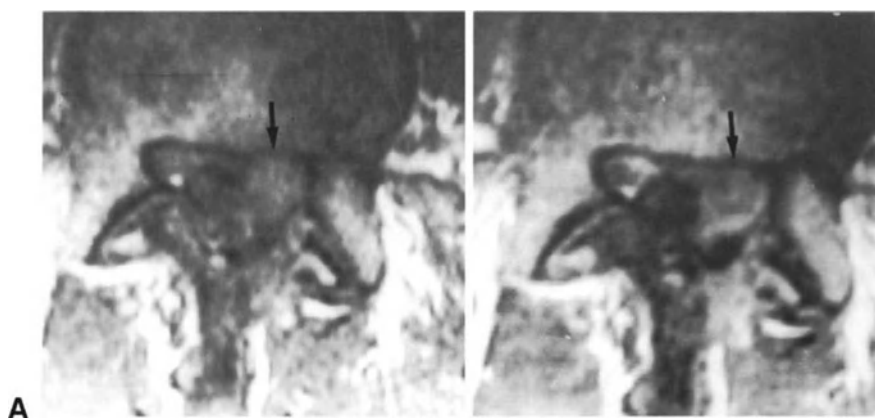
MR images of a patient with recurrent disc herniation at L4-L5 level 16 months after primary discectomy. (A) Spin-echo T1-weighted axial image before gadolinium injection. The left nerve-root canal is occupied by tissue of uncertain origin (arrow). (B) After administration of gadolinium, the tissue does not exhibit an increased signal intensity, but appears to be surrounded by a band of hyperintense signal (arrow). The latter indicates a fragment of disc tissue surrounded by epidural scar.
